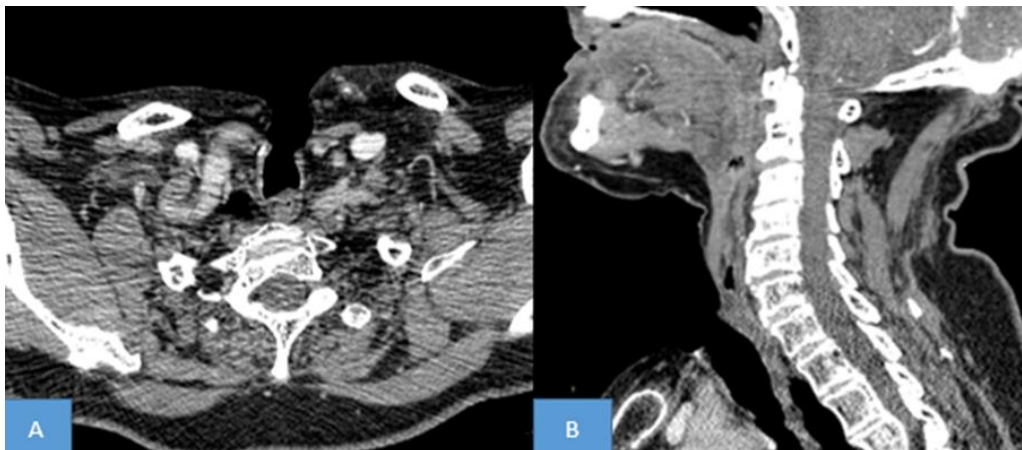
Cervical CT scan, axial (A) and sagittal (B) sections after injection of contrast product: Absence of abnormal density or contrast enhancement of the soft tissues of the neopharynx in a 72-year-old patient operated for squamous cell carcinoma of the larynx
